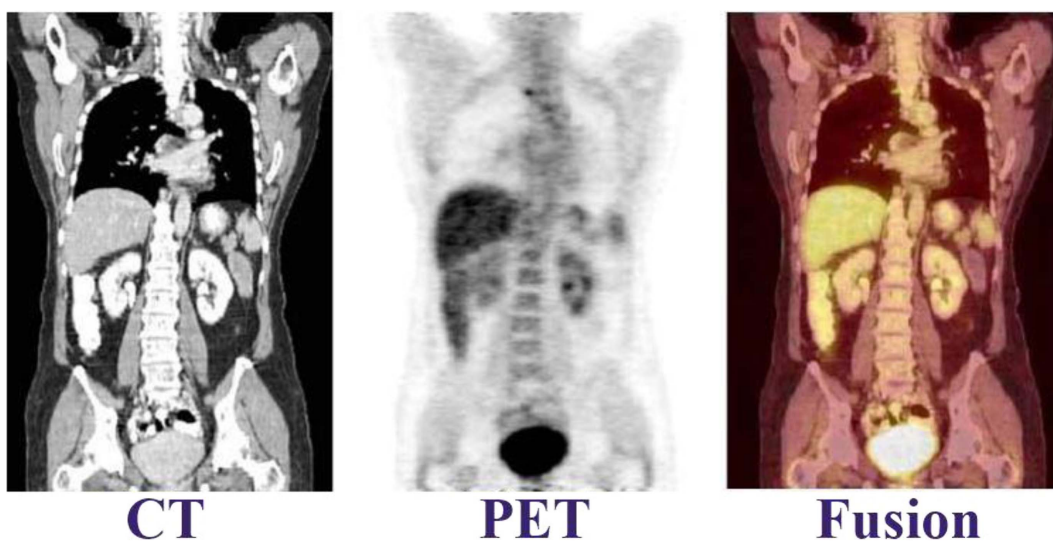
(Color online) 2D and 3D of PET-CT acquisition images for evaluation of medical image quality. Fusion imaging of PET and CT.
